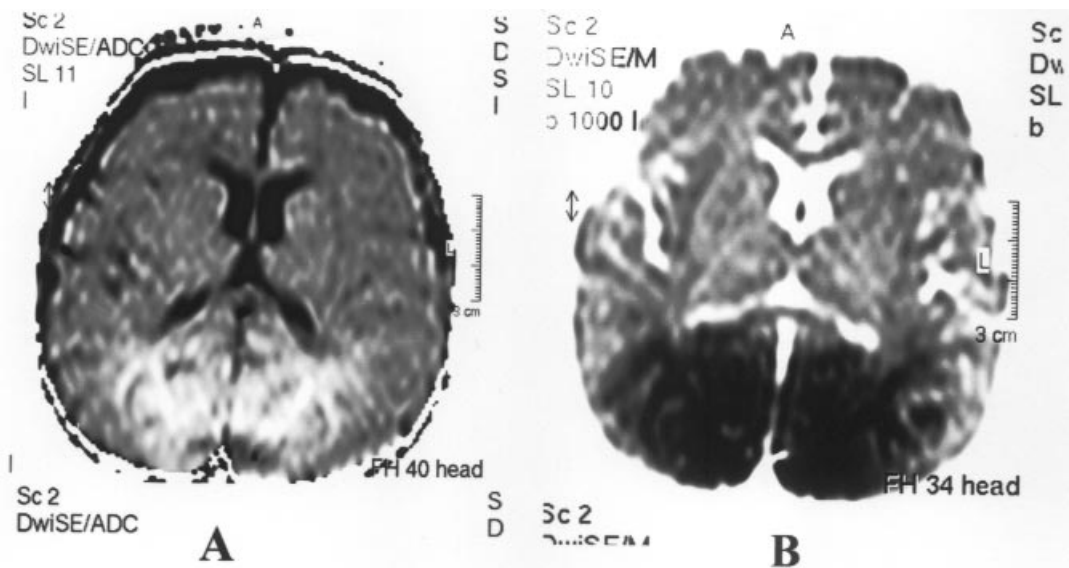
Diffusion MRI shows signal changes in the bilateral parasagittal area with corticomedullary involvement, having A) hypointense signal characteristics in ADC map image, B) hyperintense signal characteristics in b:1000 image.
